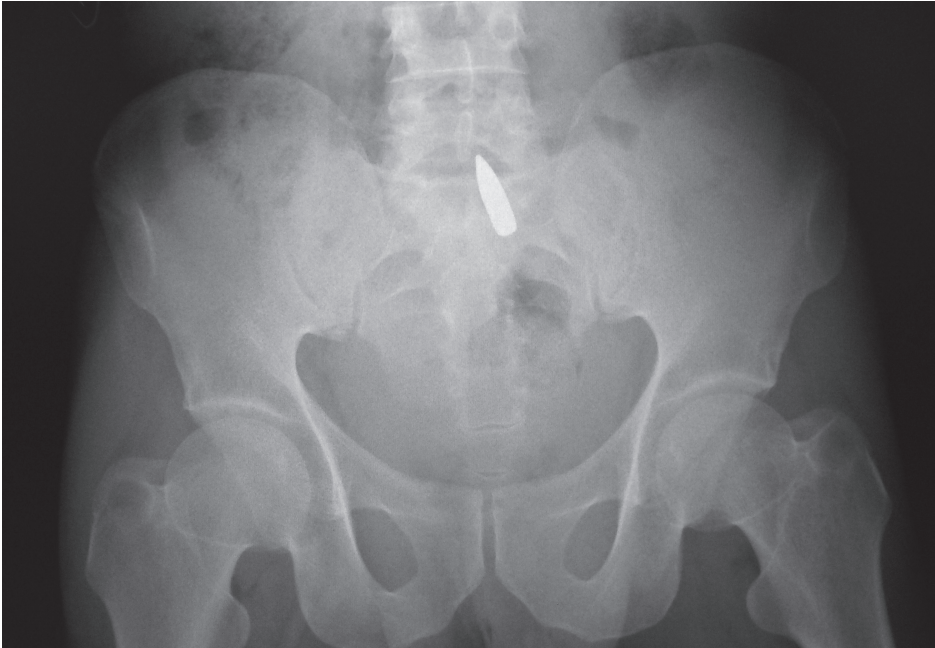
X-ray image: projectile at the level of the promontory of the sacral spine
